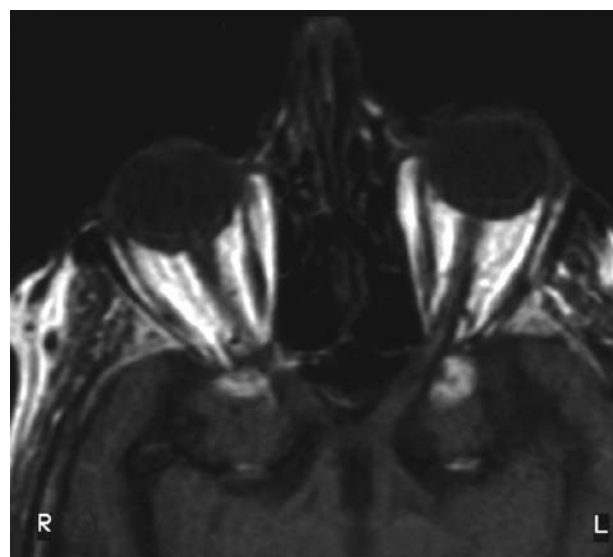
Contrast-enhanced MRI reveals right optic nerve enhancement (T1 spin echo).
